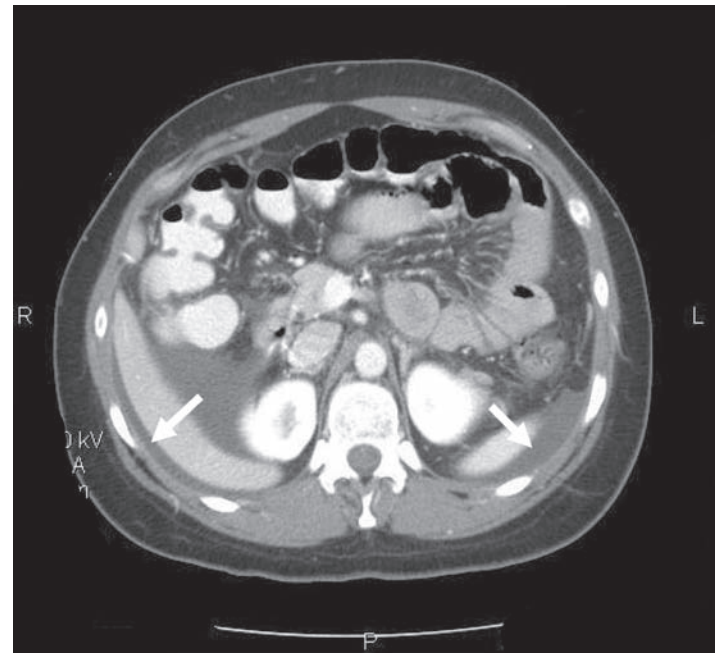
More cephalad section of the same computed tomography revealing areas of dependant ascites (arrows).
